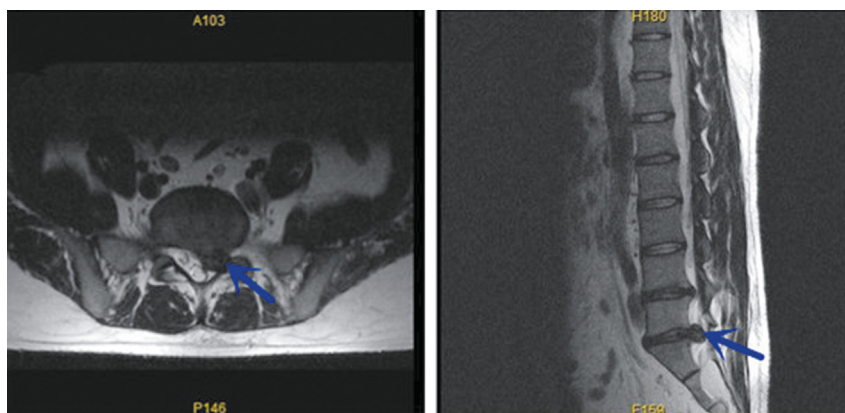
Preoperative T2-weighted magnetic resonance imaging scans in the axial plane and sagittal plane show a large lumbar disc herniation.
